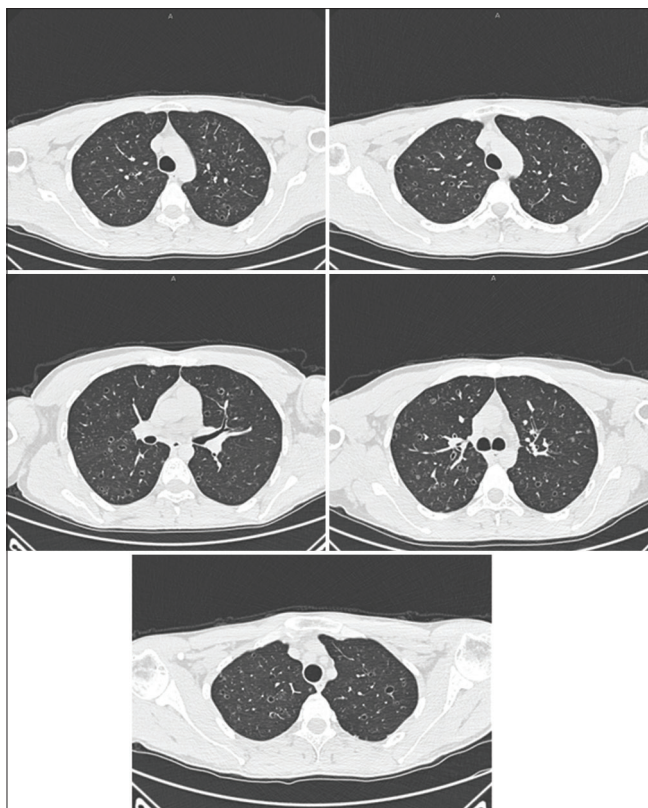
Thorax high-resolution computed tomography of case 2. The axial cross-sections were demonstrating bilateral multiple diffuse solid nodular cysts and cavities in small airways
